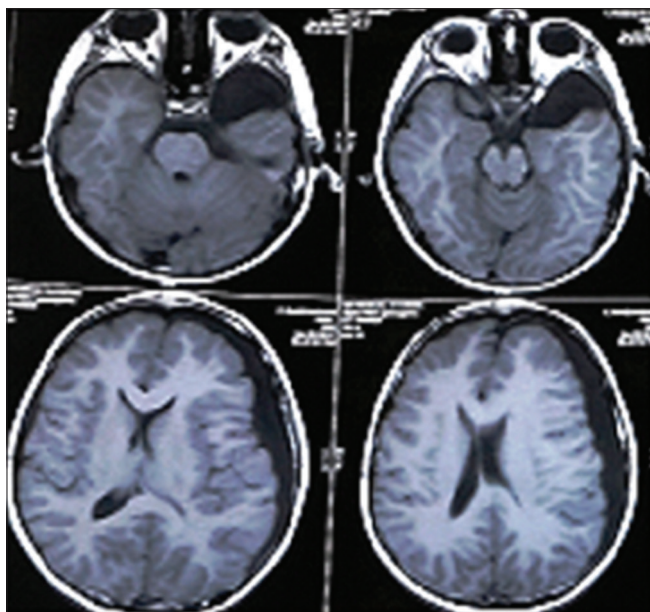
Magnetic resonance imaging brain T1W image showing subdural hypointensity in the left frontotemporal region and left middle cranial fossa suggestive of arachnoid cyst with subdural hygroma and mass effect
